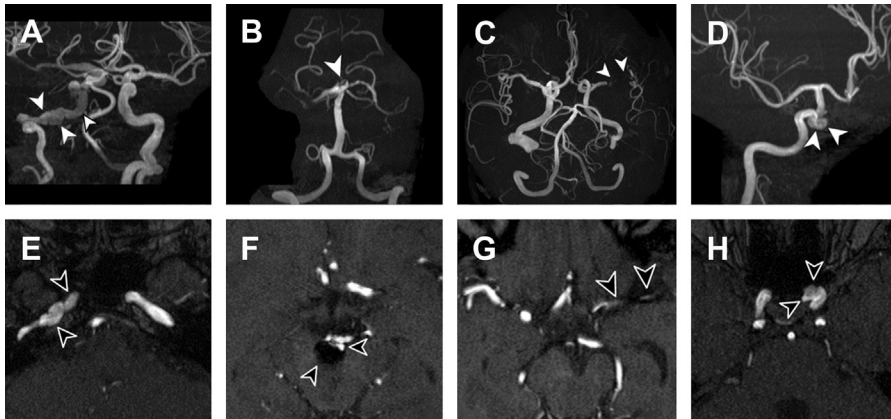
3D maximum-intensity projection images and corresponding to time-of-flight (TOF) MRA source images from 4 cases. (A–E) Fibromuscular dysplasia of the right internal carotid artery. (B–F) Basilar tip aneurysm following coiling. The arrowheads in (F) point out the residual flow in the basilar tip and the large susceptibility artifact caused by the coils. (C–G) Stent in the left middle cerebral artery (MCA) after acute stroke. No flow signal is seen in the MCA, which is again caused by susceptibility artifact and not the complete lack of flow, evident by the intact signal in the peripheral MCA branches. For stent evaluation, therefore, CT angiography is recommended. (D–H) Saccular aneurysm on the intracavernous segment of the left internal carotid artery (ICA). This location is more frequent than one would expect.
